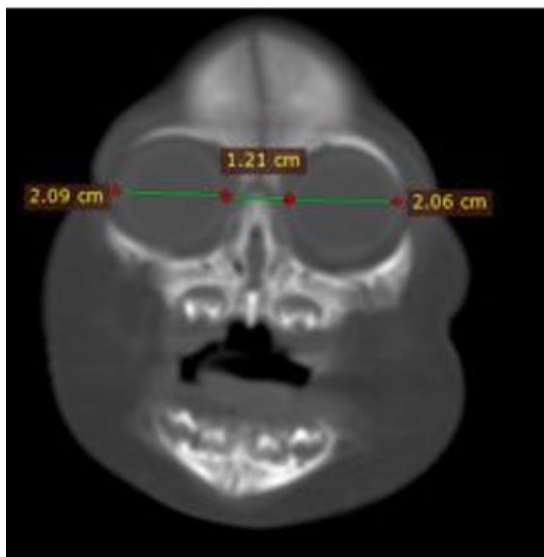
Coronal CT image showing ocular hypotelorism.
